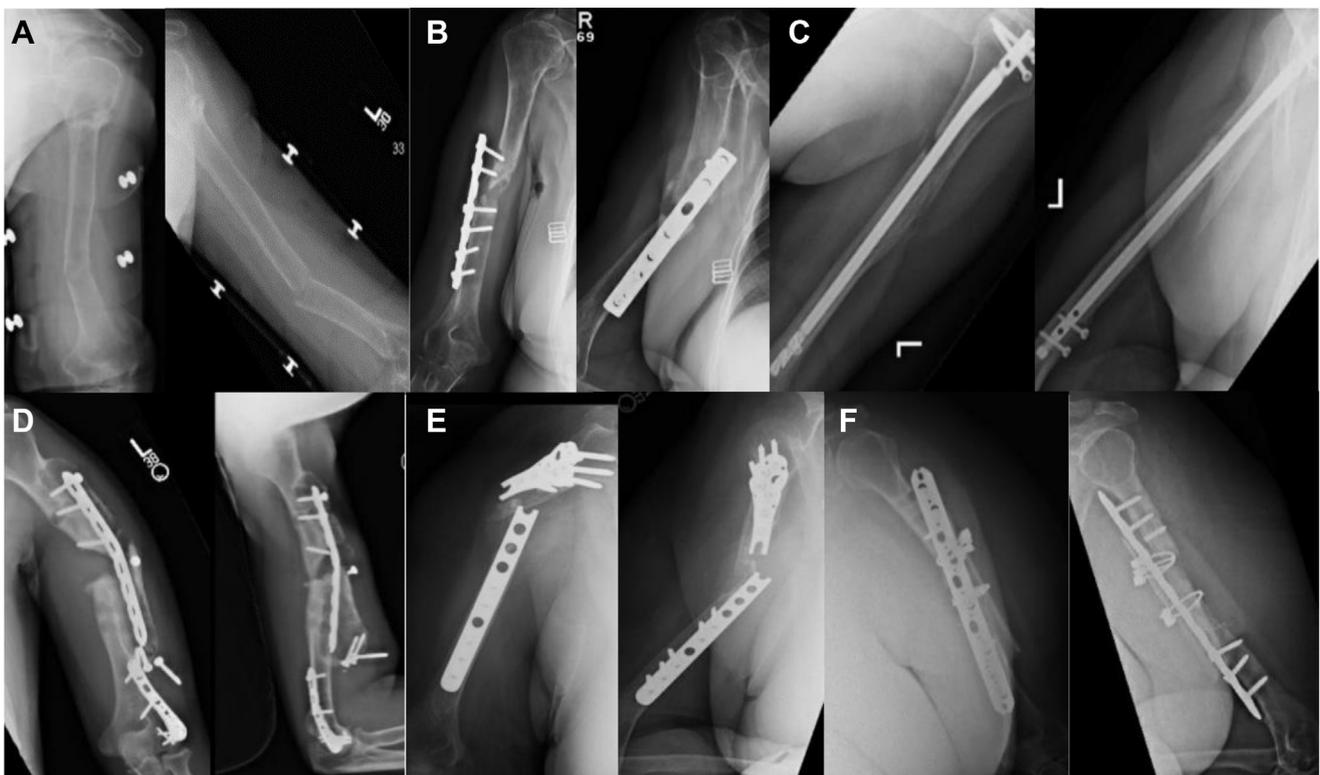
Radiographs of nonunions after nonoperative management, inadequate fixation and appropriate fixation: Radiographs demonstrate segmental nonunion of the proximal and distal humerus initially treated nonoperatively (A), inadequate proximal screw fixation of a humeral fracture (B) and constructs with varying degrees of appropriate fixation prior to magnetic IMN (A-F), including revision IMN with grafting (C), periprosthetic nonunion (D), failure of revision open reduction internal fixation (ORIF), and grafting (E) and failure of revision ORIF with strut allograft (F).
